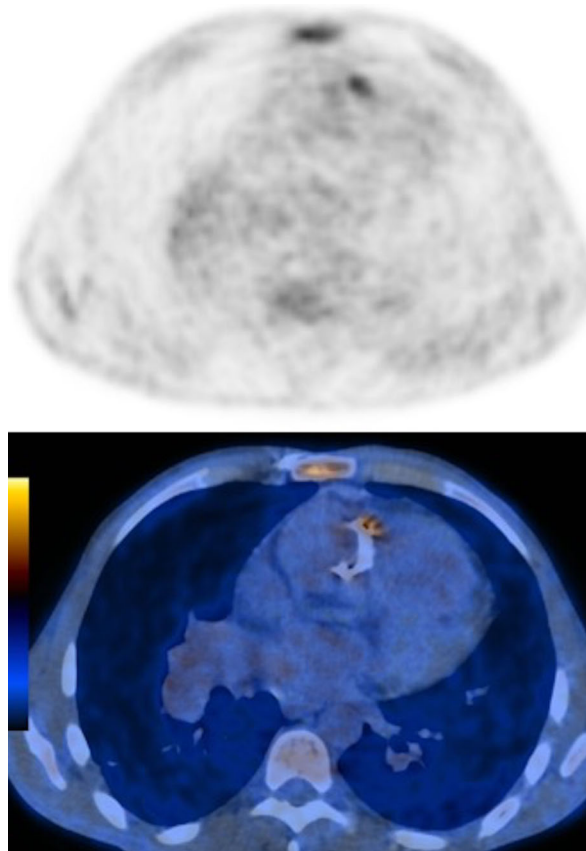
Maximum intensity projection of 18F-FDG-PET and PET-CT, on axial view at level of mechanic aortic valve. 18F-FDG-PET (up) revealed maximal FDG uptake with maxSUV:3 surround of mechanic aortic valve, location confirmed on PET/CT fusion images (down). All images keep FDG uptake on sternum.
